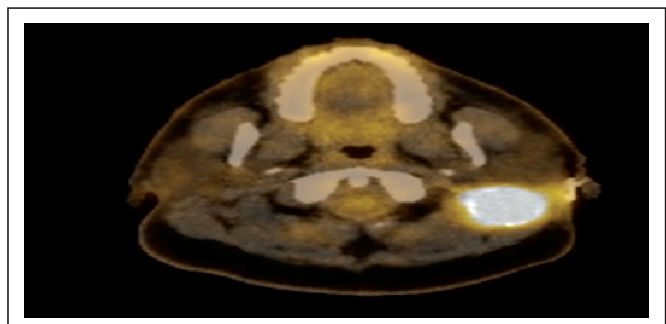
A well margined FDG avid solitary lesion in left mastoid/posterior auricular lesion of SUV max 15.1 measuring 61 x 37mm.
